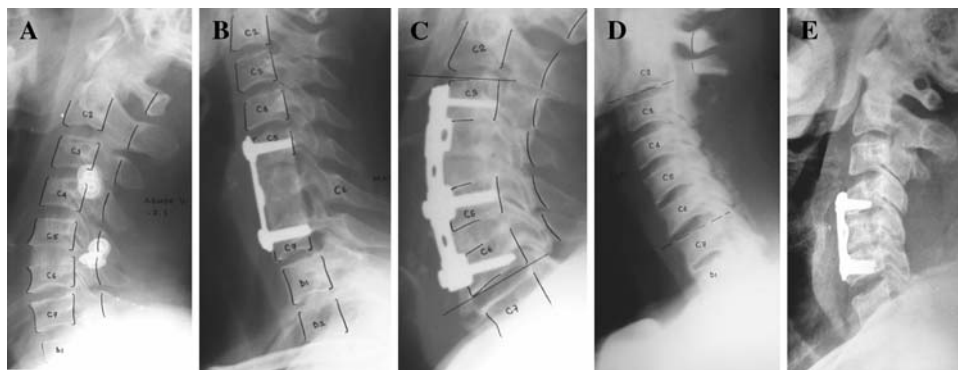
Postoperative lateral radiographs of various POCs. a C5-6 anterior cervical discectomy and fusion (POC I). b C6 corpectomy and instrumented fusion using iliac crest autograft (POC II). c C4 corpectomy and C5-6 discectomy and instrumented fusion (POC III).
